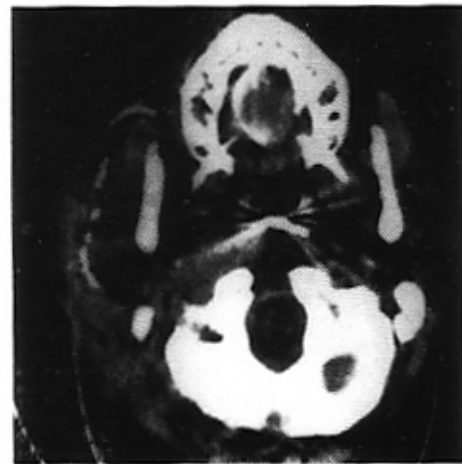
Axial CT cuts at the level of the mandible:
